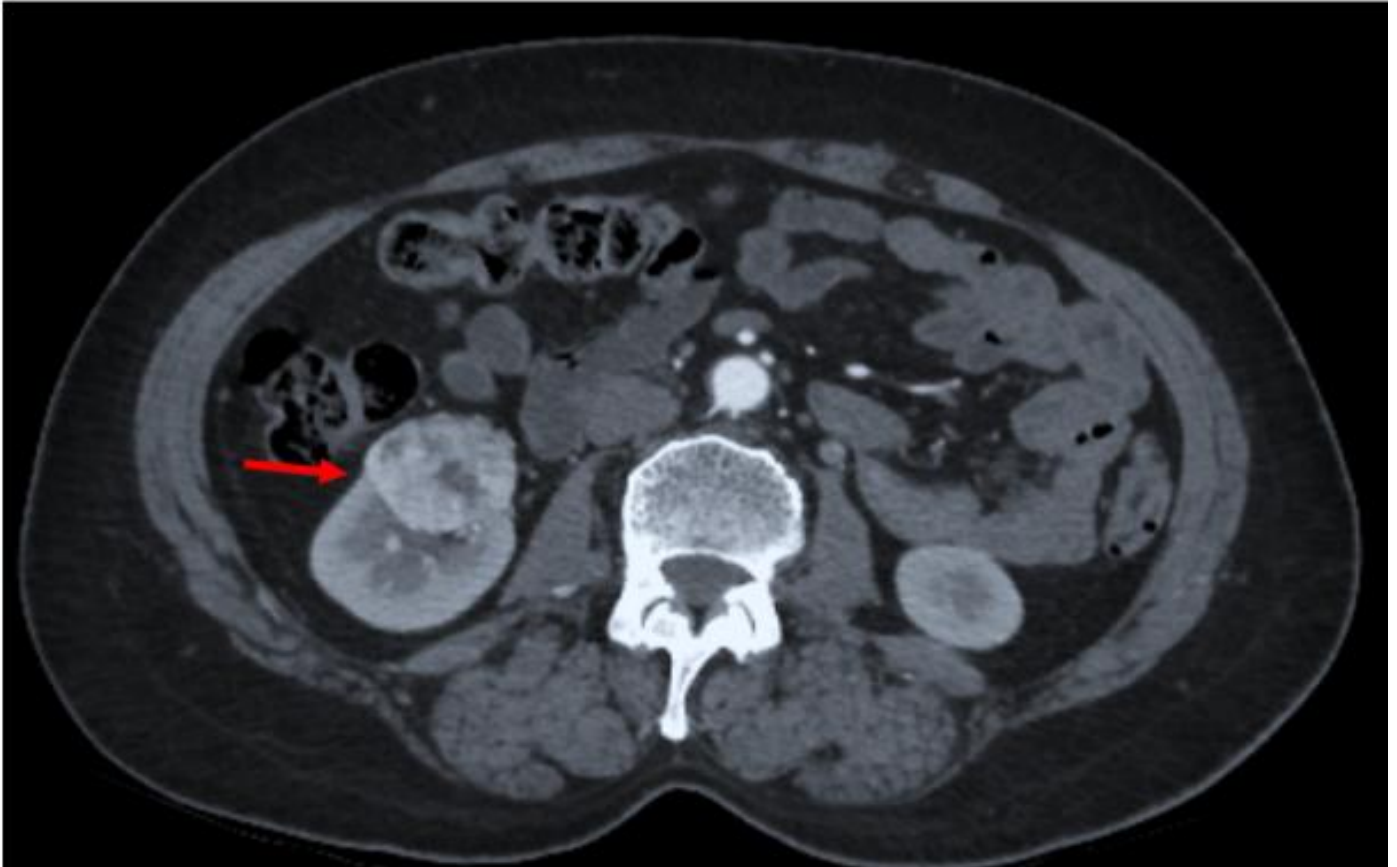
Axial Section of Contrast Enhanced CT Scan Showing Heterogeneously Enhancing Well Circumscribed Lesion in Right kidney (Red Arrow).
